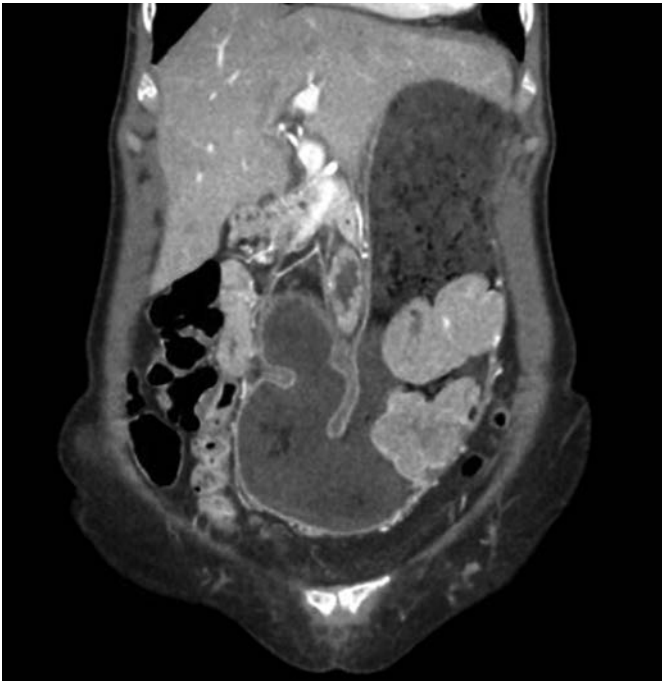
Computed tomography showing an extensive proliferative gastric wall lesion.
